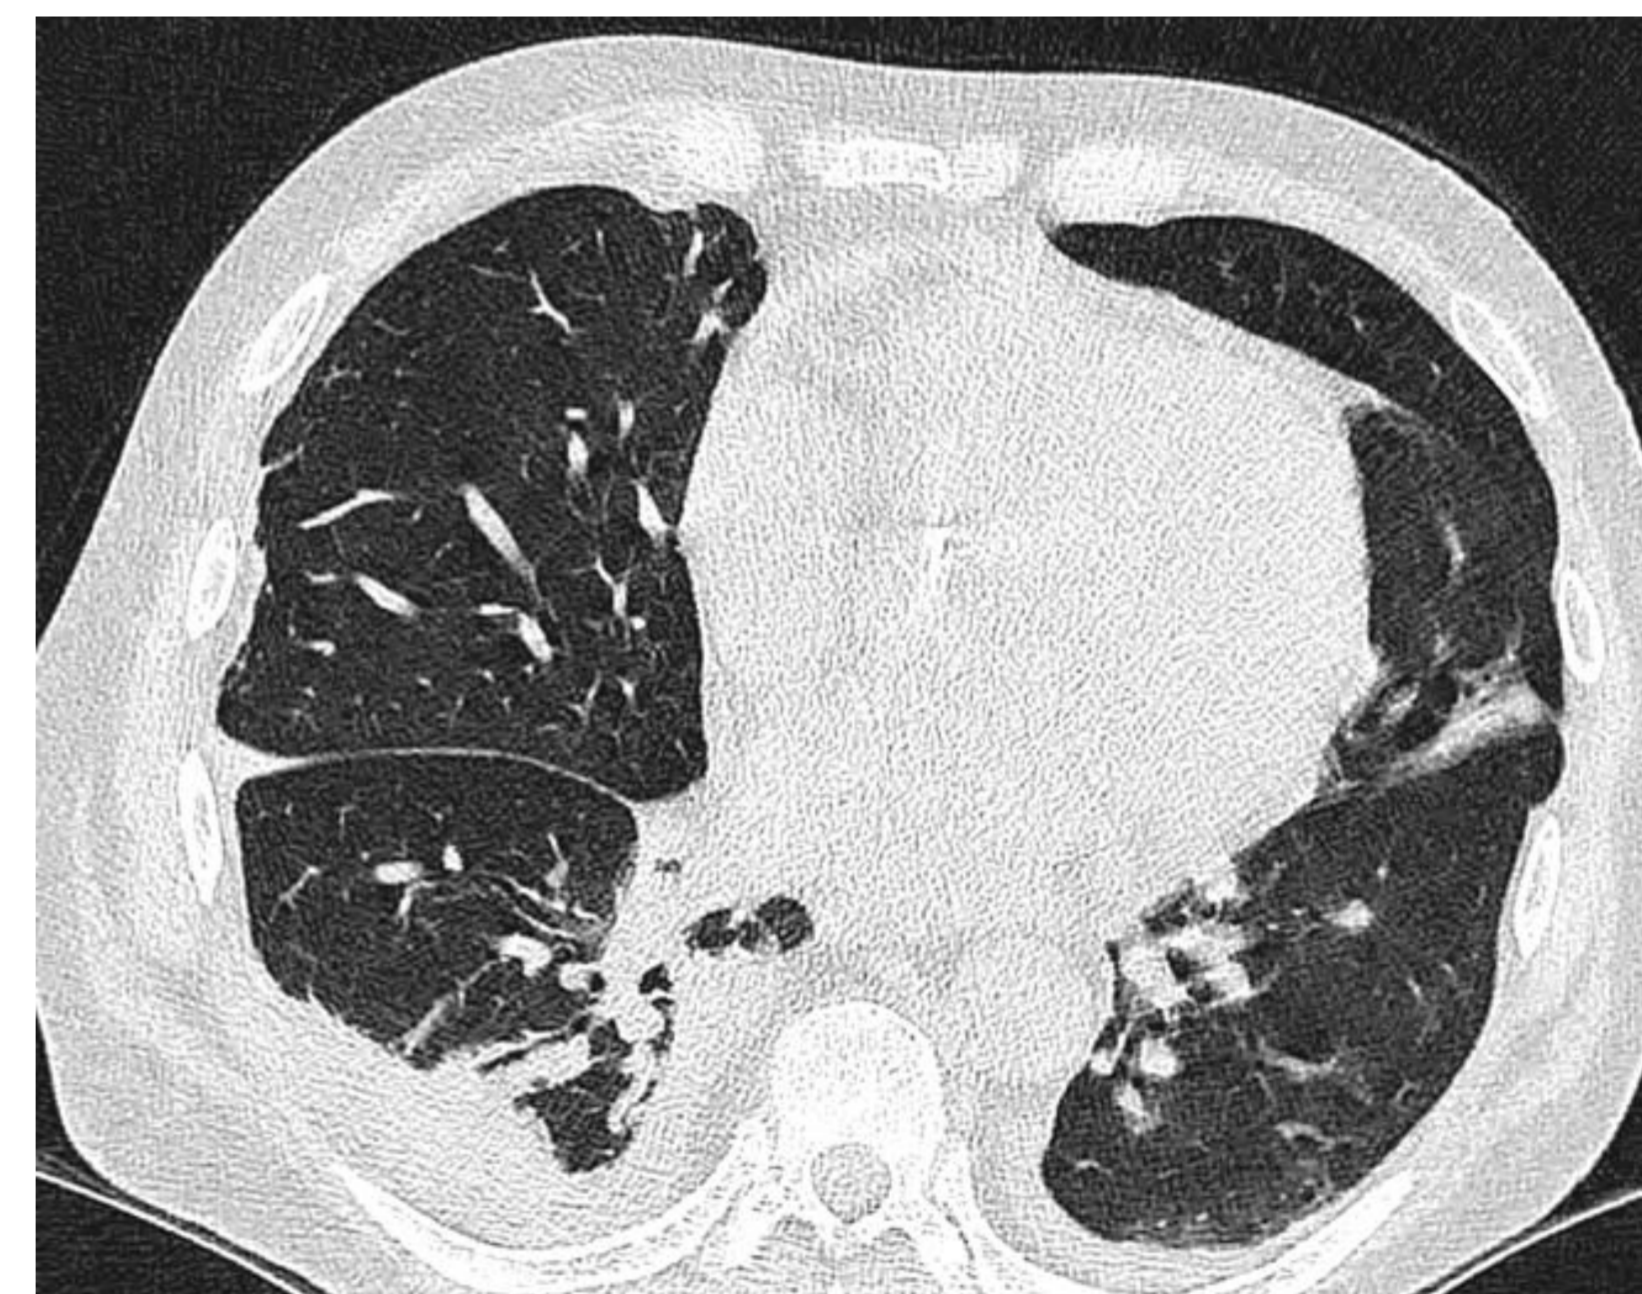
CT chest two months into treatment
